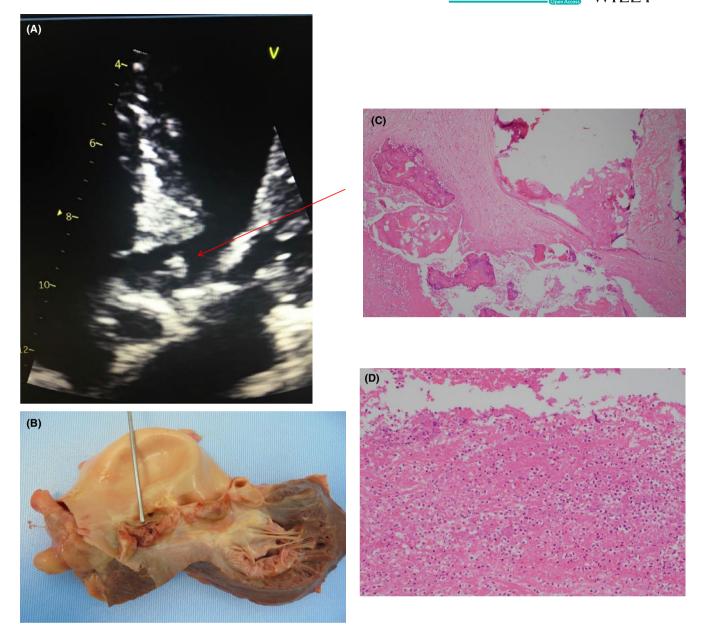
A, Echocardiographic evidence of aortic valve vegetation (Five-chamber view). B, Calcification and vegetation of the aortic valve. C, Calcified valve leaflets. D, Vegetation represented by fibrin, acute inflammation, and some bacterial colonies
